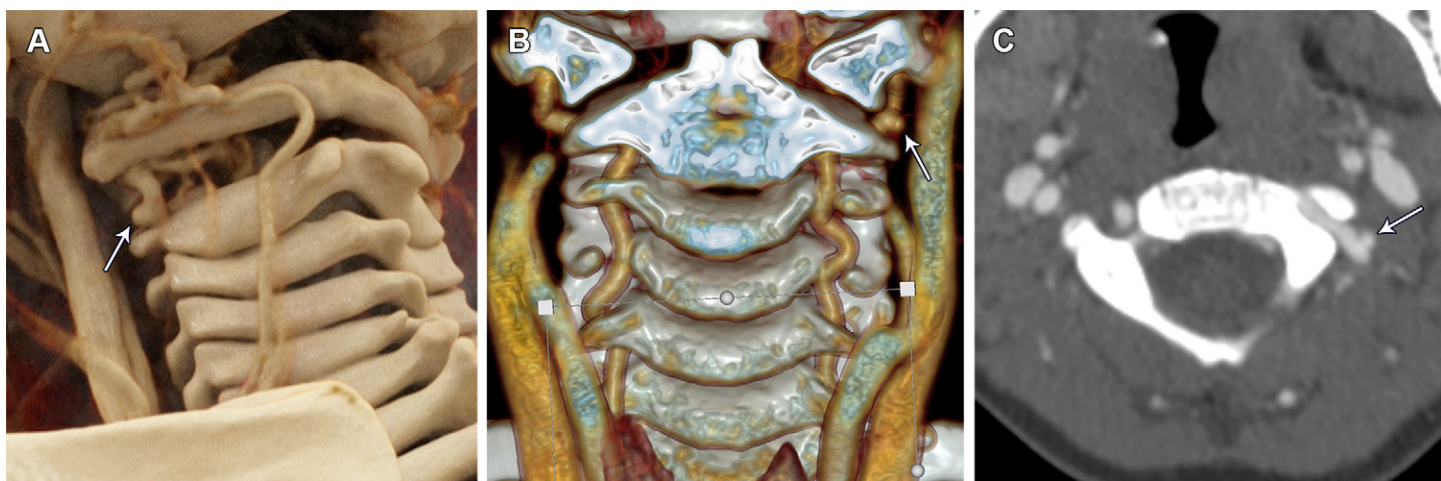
VAD with pseudoaneurysm (CASCADE section 4: a1) in a 3-year-old boy with nausea, vomiting, and ataxia. Left posterior oblique volume-rendered cinematic (A), coronal volume-rendered (B), and axial (C) CT angiograms show an outpouching from the left proximal V3 vertebral artery segment (arrow), representing a pseudoaneurysm. Pseudoaneurysms are more common than intimal flaps and may be seen at the time of initial imaging or at follow-up.
